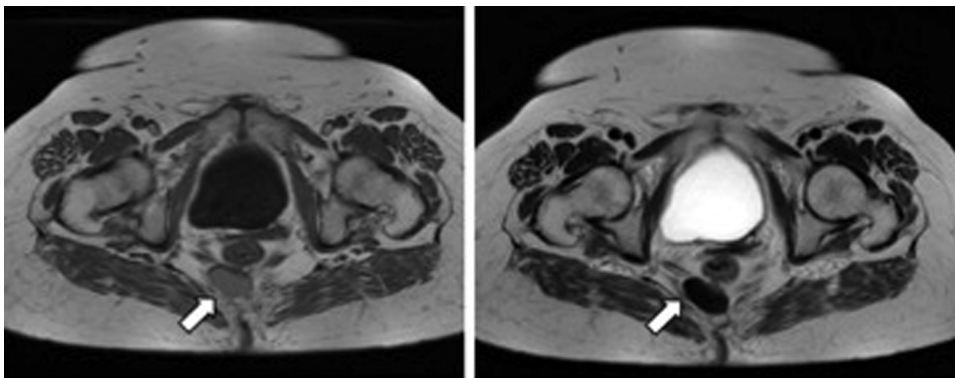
Contrast-MRI: white arrows indicate the enhancing cystic mass.
